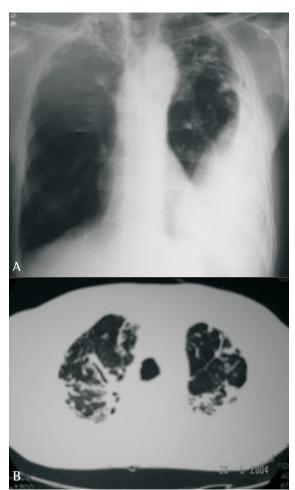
a) Chest X-ray revealing left-sided pleural effusion accompanied by bands in both upper lobes of the lungs b) Computed tomography scan of the chest revealing bronchiectasis and nodules.
